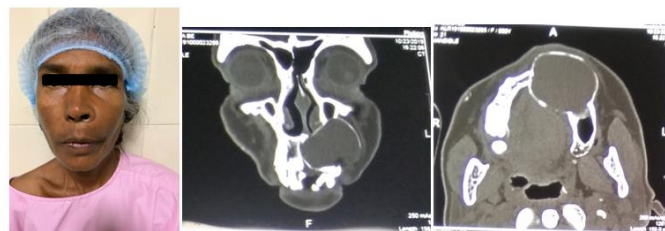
(A) Preop: CT coronal & axial view
